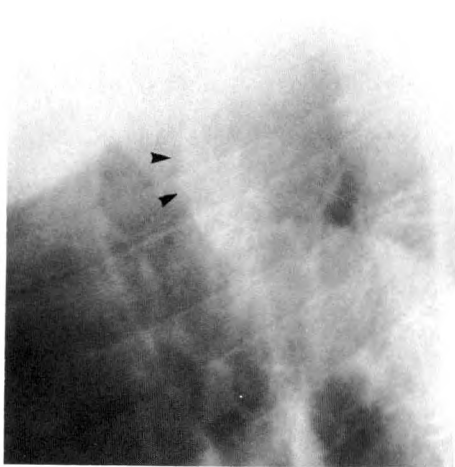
Posterior tracheal imprint. Lateral radiograph shows retrotracheal opacity of aberrant right subclavian artery associated with imprint (arrowheads) along posterior tracheal wall. (Compare with Fig. 6A.)
